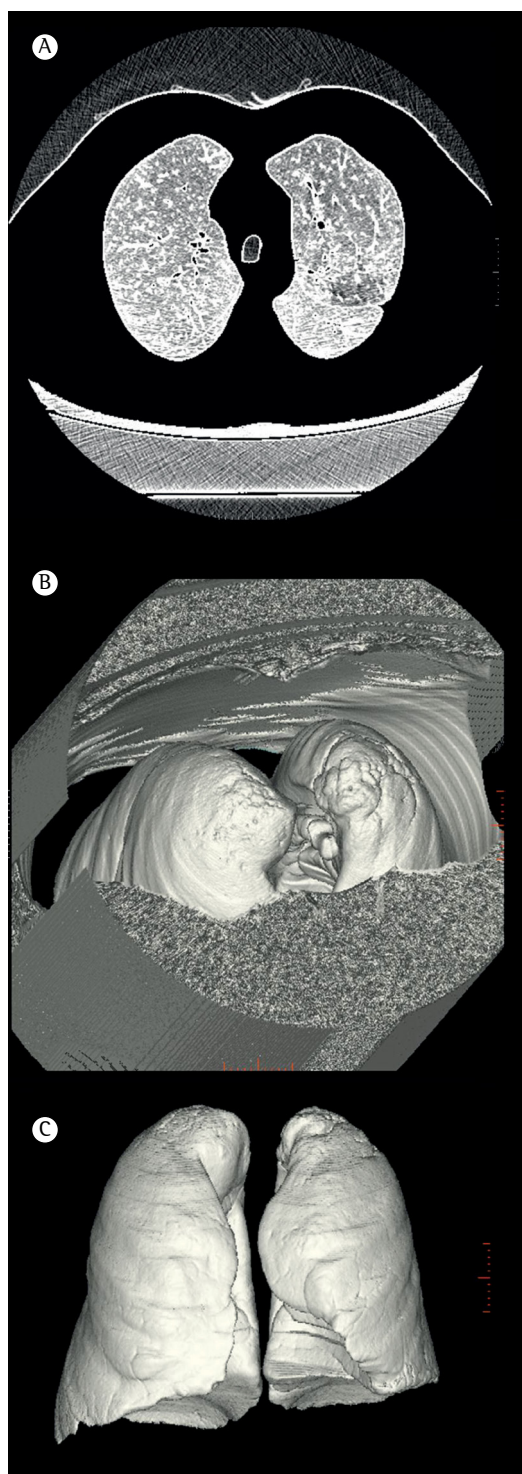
Post-processing tools. After the use of a threshold, the air inside and outside the lungs is isolated. In A, axial CT scan showing air inside and outside the lungs. In B, three-dimensional (3D) volume rendering of the same data. In C, 3D volume rendering of total lung volume after the exclusion of air outside the lungs.
